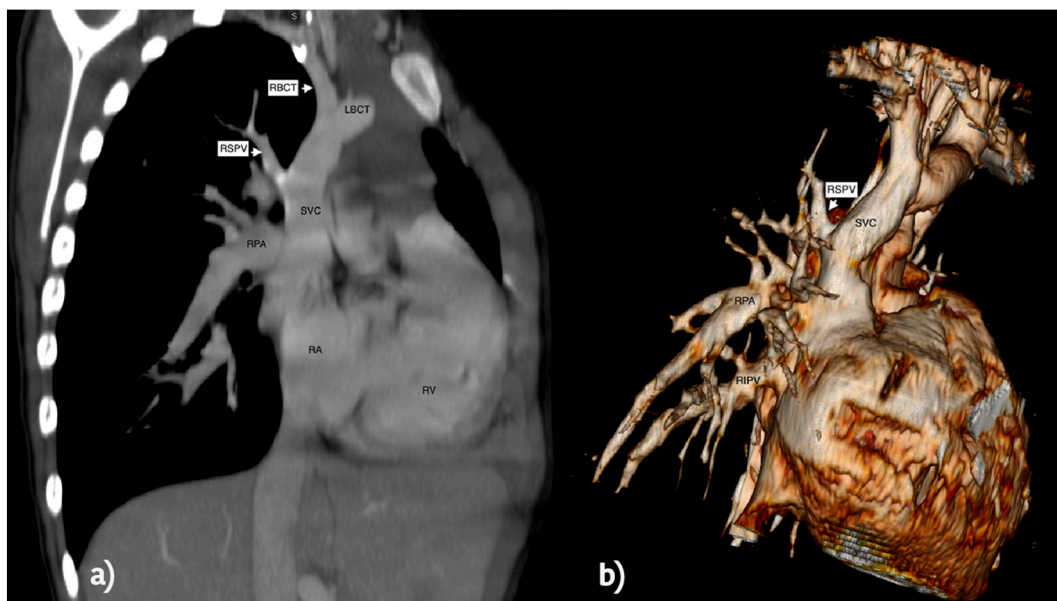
Contrast-enhanced computed tomography para-sagittal MPR (a e c) and VR reconstruction (b) of anomalous right pulmonary veins drainage in SVC in a case of Unilateral Anomalous Pulmonary Venous Connection. SVC = Superior vena cava; RA = Right atrium; RV = Right ventricle; PA = Pulmonary artery; RSPV = Right superior pulmonary vein; RIPV = Right inferior pulmonary vein; LBCT = Left brachio-cephalic trunk; RBCT = Right brachio-cephalic trunk.
